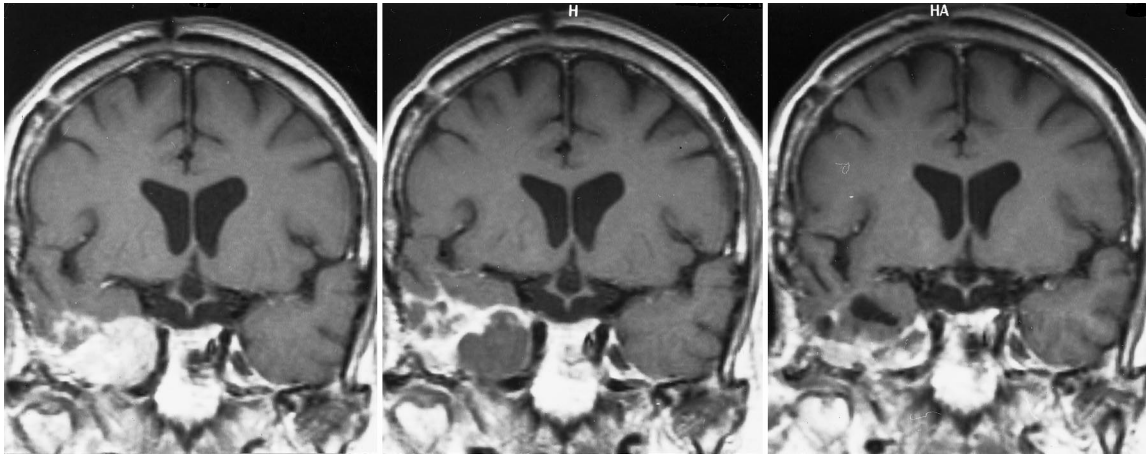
Case 1. Coronal T<sub>1</sub>-weighted gadolinium-enhanced MR images. Note the infundibulum at the bottom of the third ventricle in all three panels revealing identical slice positions. *Left:* Pretreatment MR image revealing a large meningeoma of the right sphenoid wing invading the cavernous sinus and the right temporal base. *Center:* An MR image obtained 3 months after initiation of hydroxyurea treatment revealing the meningeoma in place and unchanged in size, but with a huge clearly demarcated hypointense area indicating a significantly reduced gadolinium uptake. *Right:* An MR image obtained 6 months after initiation of hydroxyurea treatment revealing a small tumor rim in the base of the right temporal fossa. The right temporal horn, which had been compressed by the tumor mass, is now unfolded. The intracranial tumor mass was reduced by 60%.
